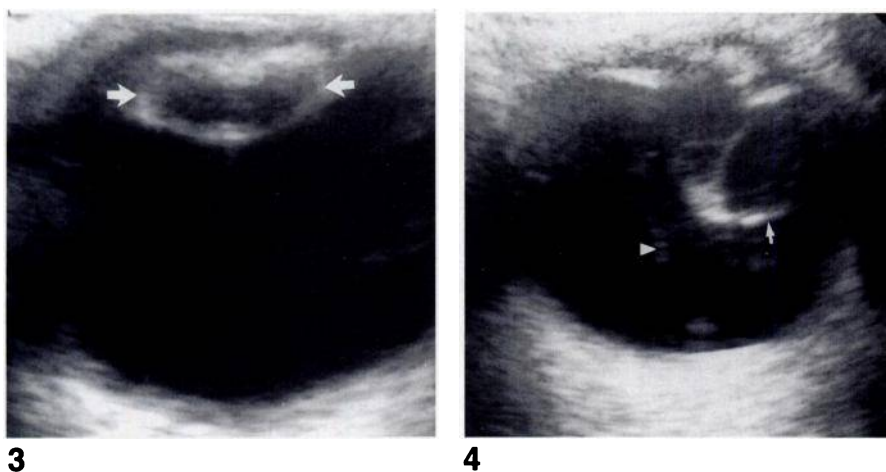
Cataract. Axial sonogram of patient with a moderately dense cataract (*arrows*) that precluded funduscopy. Sonogram shows normal vitreous and retina.
